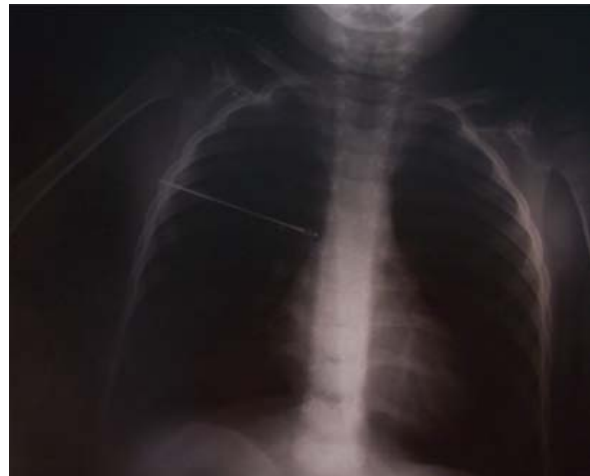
Plain thoracic x-ray shows straight pin in the second patient.
